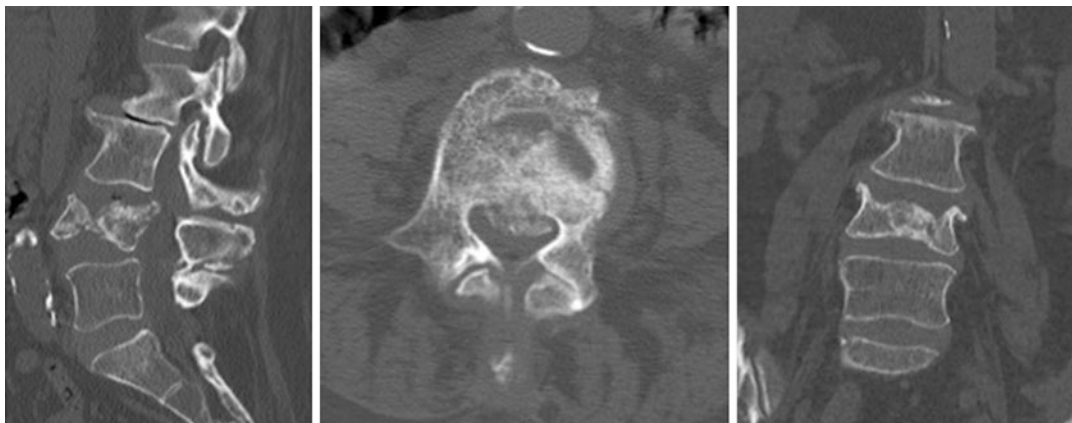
Computed tomography (CT) of a burst fracture after a fall in an 83-year-old female
